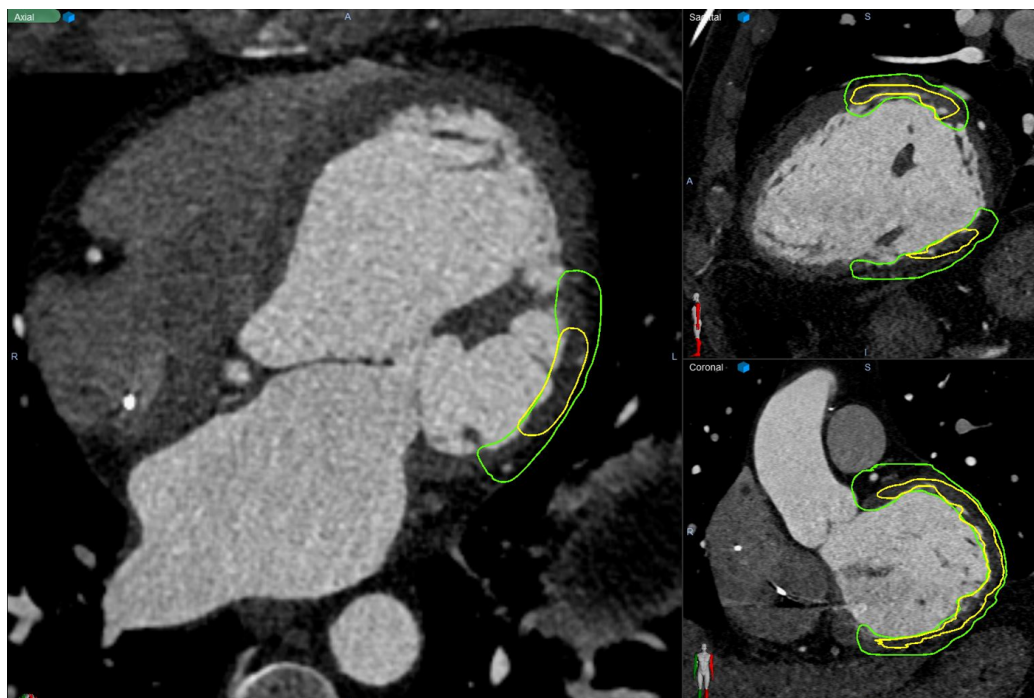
Manually defined clinical target volume (CTV, green) and the 2D-3D registered CTV (yellow) for case 4, shown on the cardiac computed tomography in axial, sagittal and coronal views.
